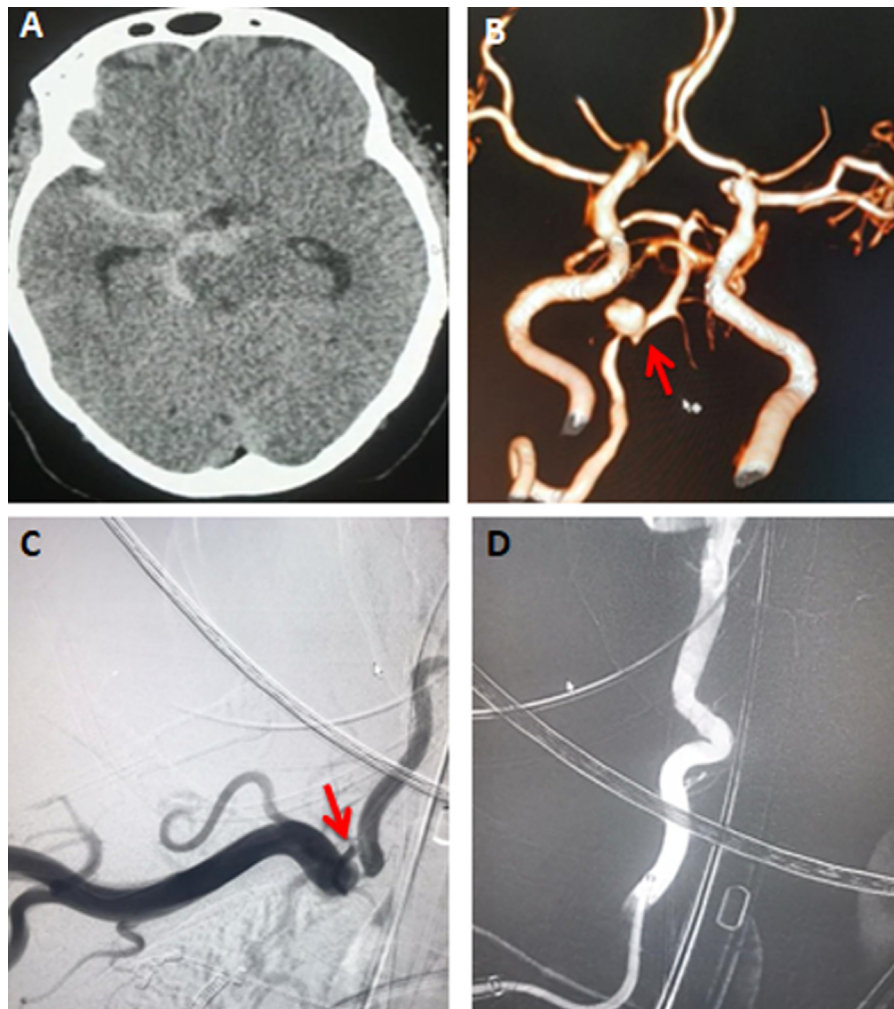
(A) An axial CT-scan shows subarachnoid hemorrhage in the suprasellar cistern (B) A CT-angiograph shows a saccular aneurysm at the vertebrobasilar junction (C) A 2D right vertebral artery angiogram shows a wide-neck saccular aneurysm at the vertebrobasilar junction with basilar fenestration (red-arrows) (D) Coils within the aneurysm sac with patency of both the limbs (red-arrows) (E, F) Check-angiograms show complete aneurysm obliteration with normal distal flow.
